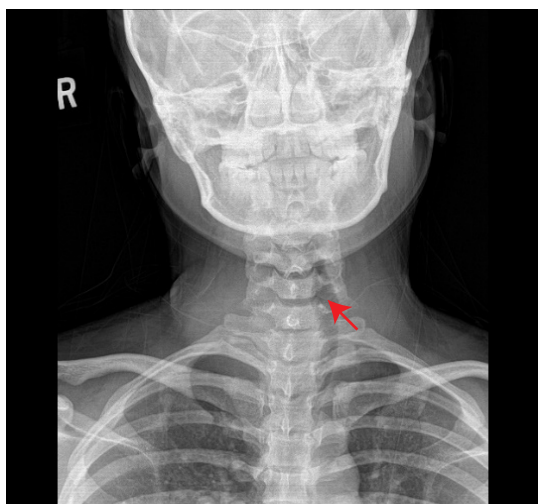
Soft tissue radiograph of the neck showed displacement of the trachea (arrow) to the left and a soft tissue shadow in the right lower neck (circle).
